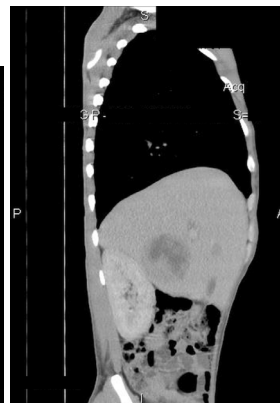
Abdomen CT+C – coronal scan plan: Heterogeneous nodular liver images with hypodense center and peripheral low enhancement.
